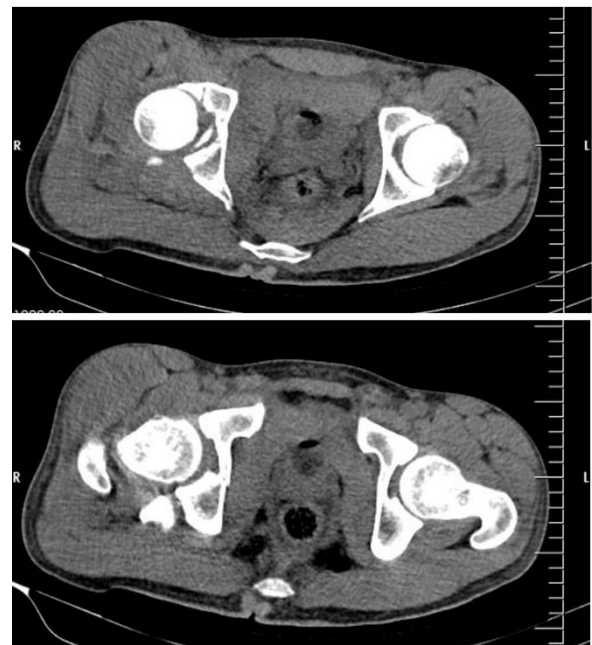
Axial CT showing right acetabular fracture with intra-articular fragments
